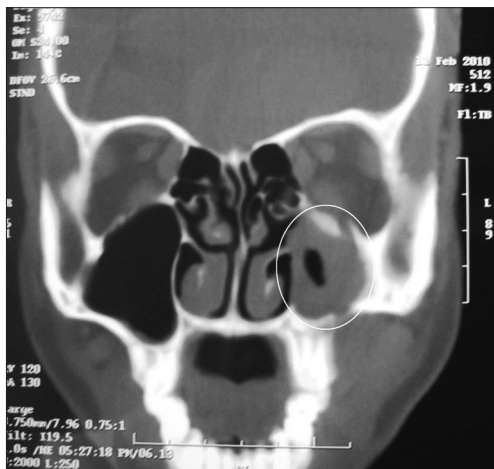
Coronal CT scan
